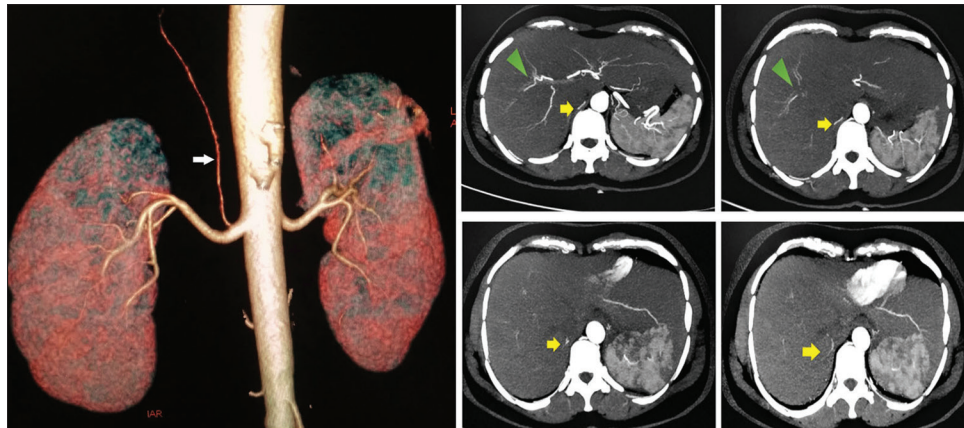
Left panel: CT angiography showing the proximal origin of accessory right hepatic artery from right renal artery (arrow). Right panel: Serial axial sections of the abdomen showing accessory right hepatic artery coursing posterior to inferior vena cava and bifurcating in segment IV of the liver (arrow). Normal right hepatic artery division is also seen (arrowhead)
